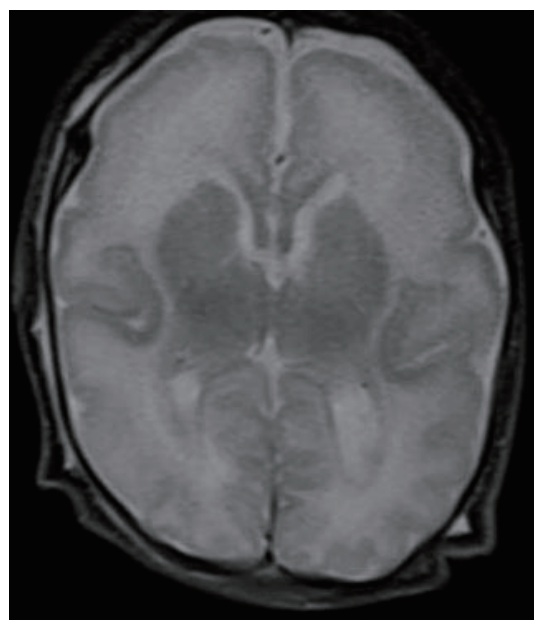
Magnetic resonance image of brain T1 weighted axial images showing thickened and flattened cortical gyri predominantly involves bilateral frontal and parietal region.
